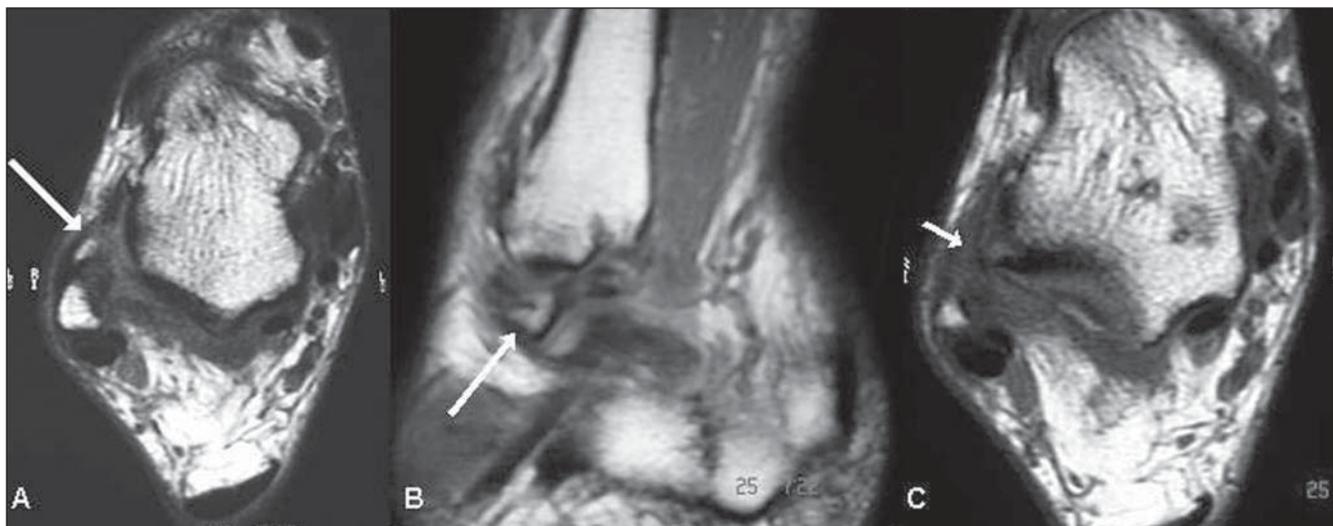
Axial (A,C), and sagittal (B) T1-weighted images of a patient presenting repetition torsion, complaining of pain in the anterolateral region of the ankle, demonstrating poorly individualized anterior talofibular ligament with an small avulsed bone fragment at the fibular insertion (long arrows). Additionally, isointense tissue thickening is observed in the region of the anterolateral joint recess (short arrow).
